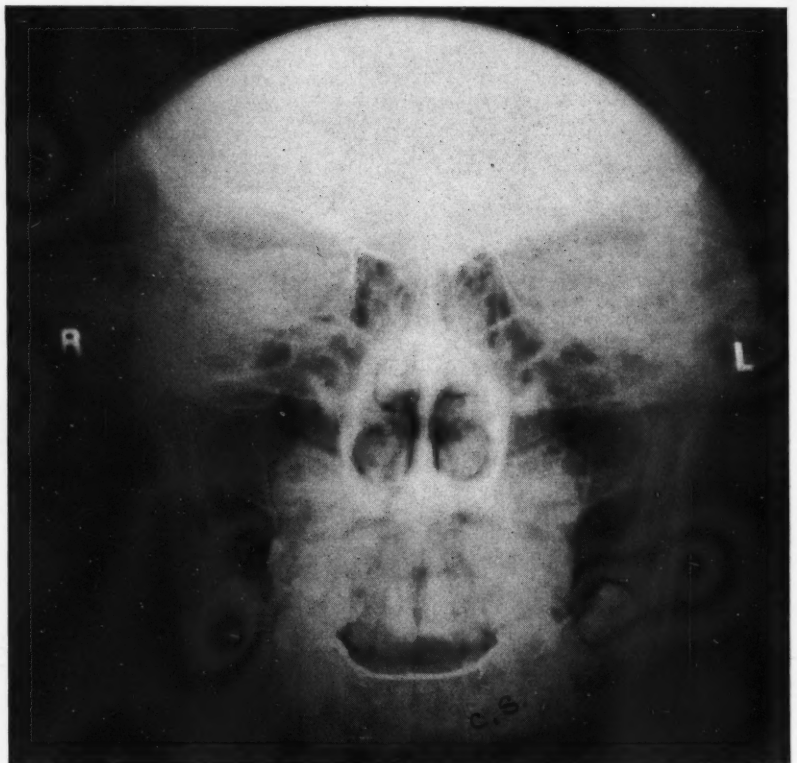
Roentgenogram of same patient shown in Fig. 4. Note disproportion of entire nasal cavity and nasal septum to the internal anatomy of face.
